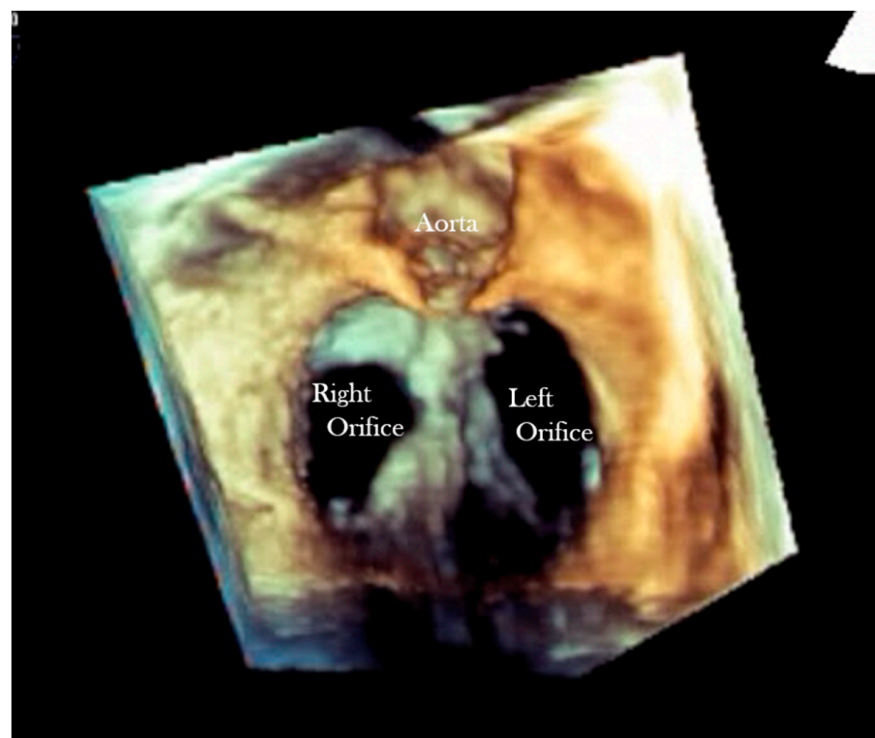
Short axis 3D echocardiographic section in a heart with AVSD and two valve orifices.
